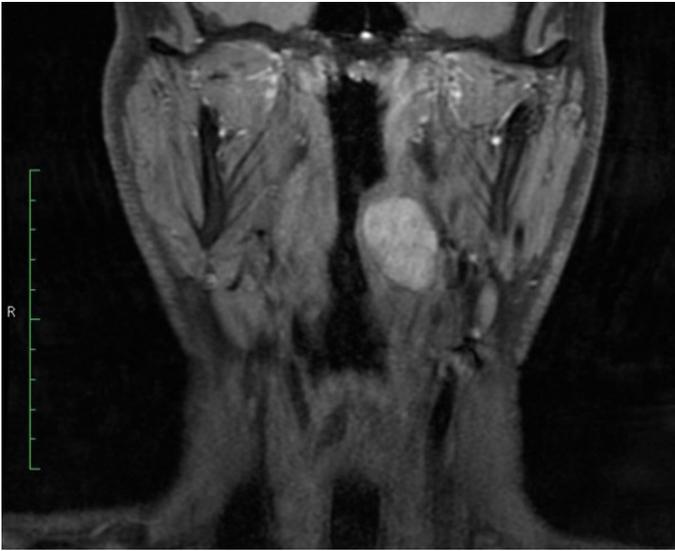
Frontal MRI of the head in the T2-weighted sequence after administration of contrast agent – hyperintense lesion showing a tumor of the left posterior wall of pharynx.
